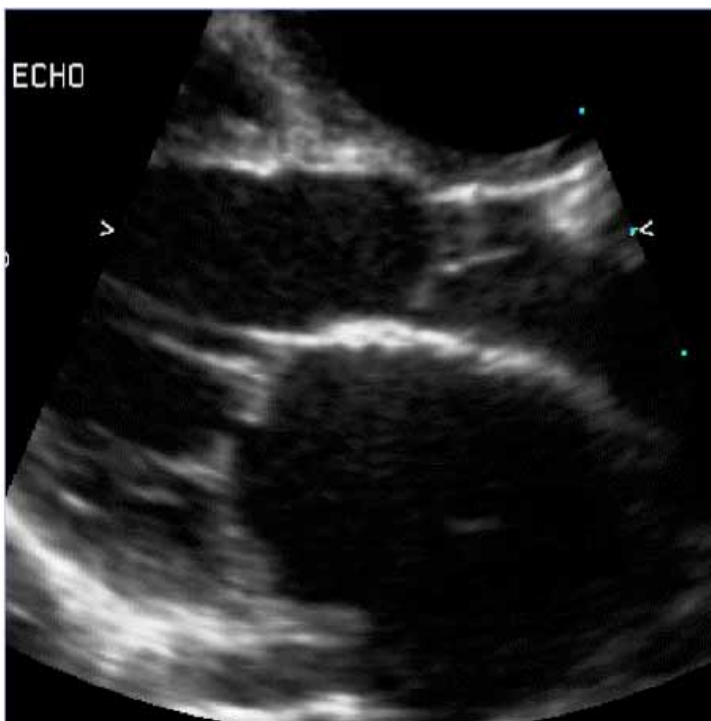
Parasternal long axis view showing anterior mitral valve leaflet coapting superior to the posterior leaflet with lack of complete coaptation.
